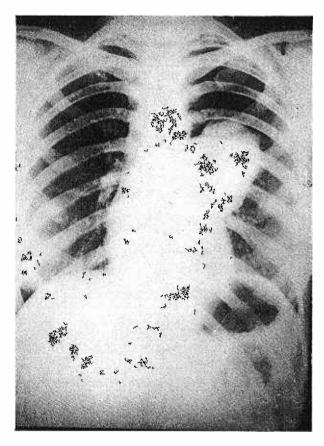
Chest X-ray. The left mediastinal tumour is well shown.
